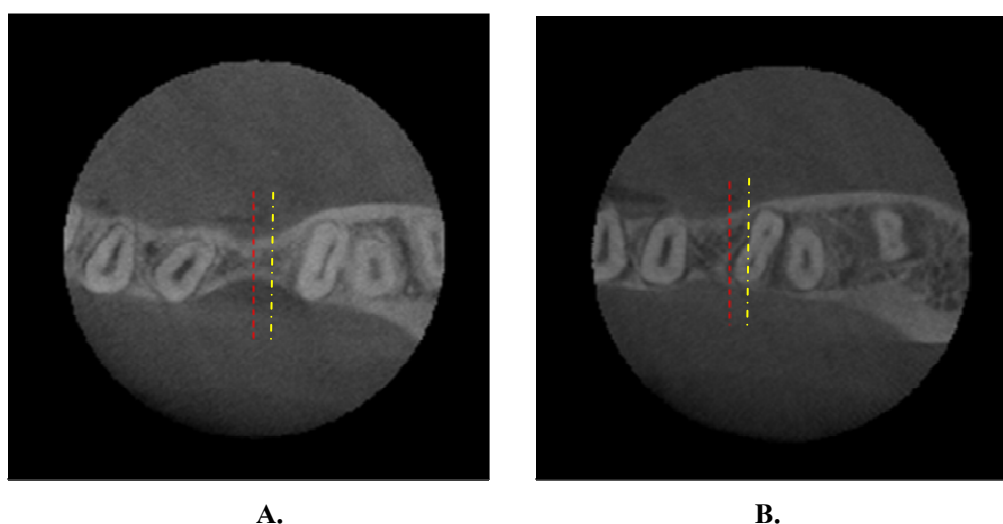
CBCT (axial section) was used to compare the bucco-lingual width of edentulous ridge before decortications (A) and 3 months after extraction space closed (B), at the narrowest (red line) and at the mesial root of mandibular second molar (yellow line).
